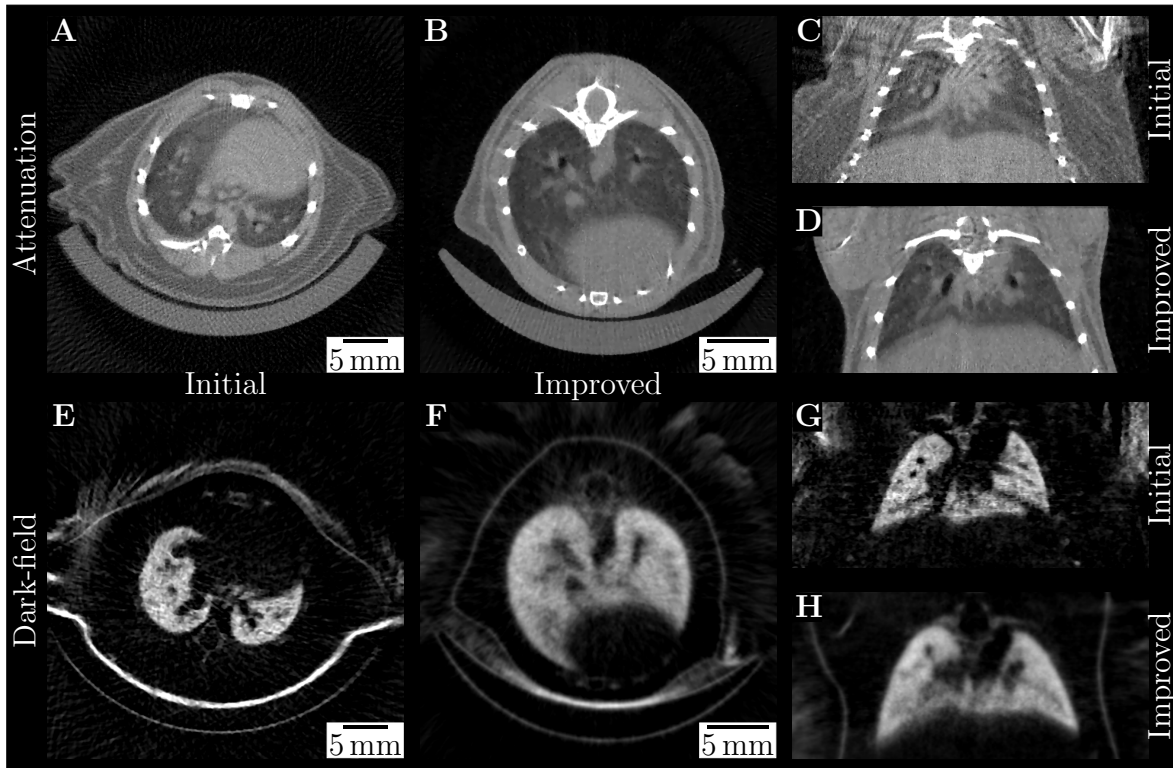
Comparison of the *in-vivo* measurements. Exemplary slices of attenuation (top row) and dark-field (bottom) CT using the initial (A, C, E, G) and improved (B, D, F, H) setup configuration. All figures are scaled for best visual appearance and consistent within the respective modality. The scalebars are valid for the respective setup configurations and contrast modalities. Figure partly adapted from [Umkehrer, 2019].
